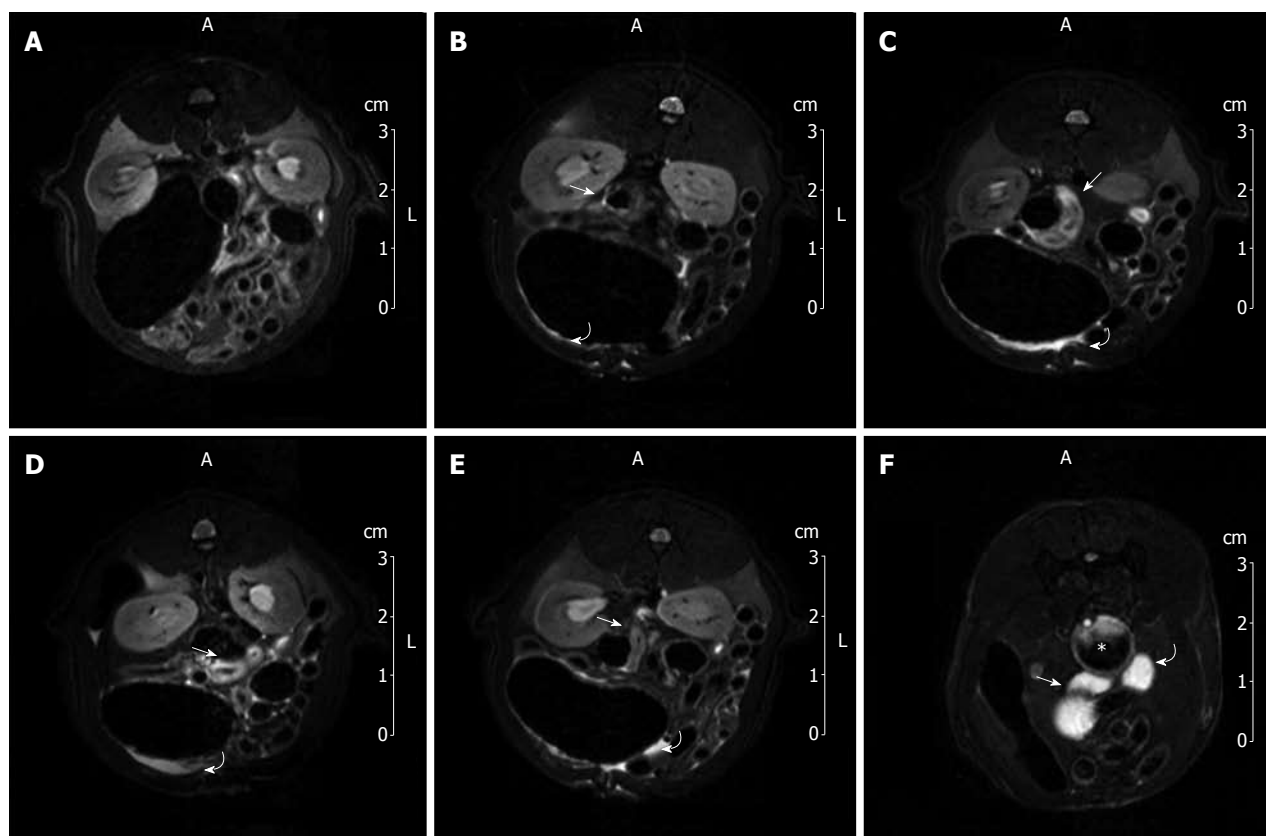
7T magnetic resonance imaging investigation. A: Image of a 7T magnetic resonance imaging (MRI) abdominal scan before inferior mesenteric artery (IMA) ligation; B: A 7T MRI abdominal scan 1 h after IMA ligation; C: At 4 h after IMA ligation; D: At 6 h after IMA ligation; E: At 8 h after IMA ligation; F: Image of 7T MRI colon enema.
